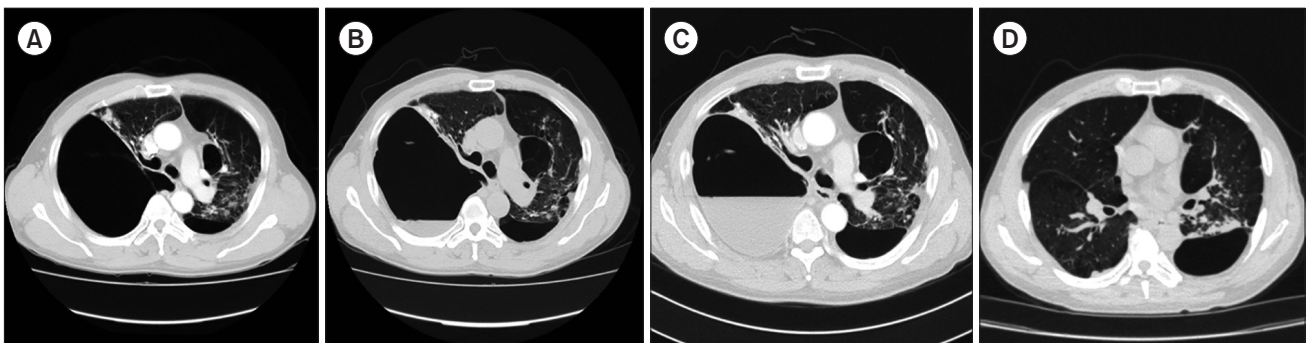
Changes in chest computed tomography images over time. (A) Two years before admission, there was a large thin-walled subpleural bulla in the right lung; (B) 9 days before admission, there was an air-fluid level within the bulla, suggestive of an infection; (C) on admission, there was increased fluid within the bulla; and (D) after tuberculosis treatment, resolution of the infectious bulla (7 months after diagnosis) was observed.
